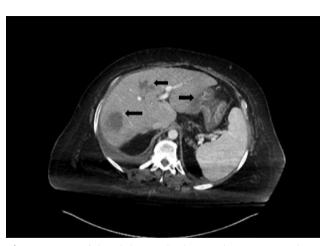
CT of the abdomen/pelvis with iv contrast demonstrating liver mass decrease after embolization. Black arrows indicate the significantly decreased liver masses.
